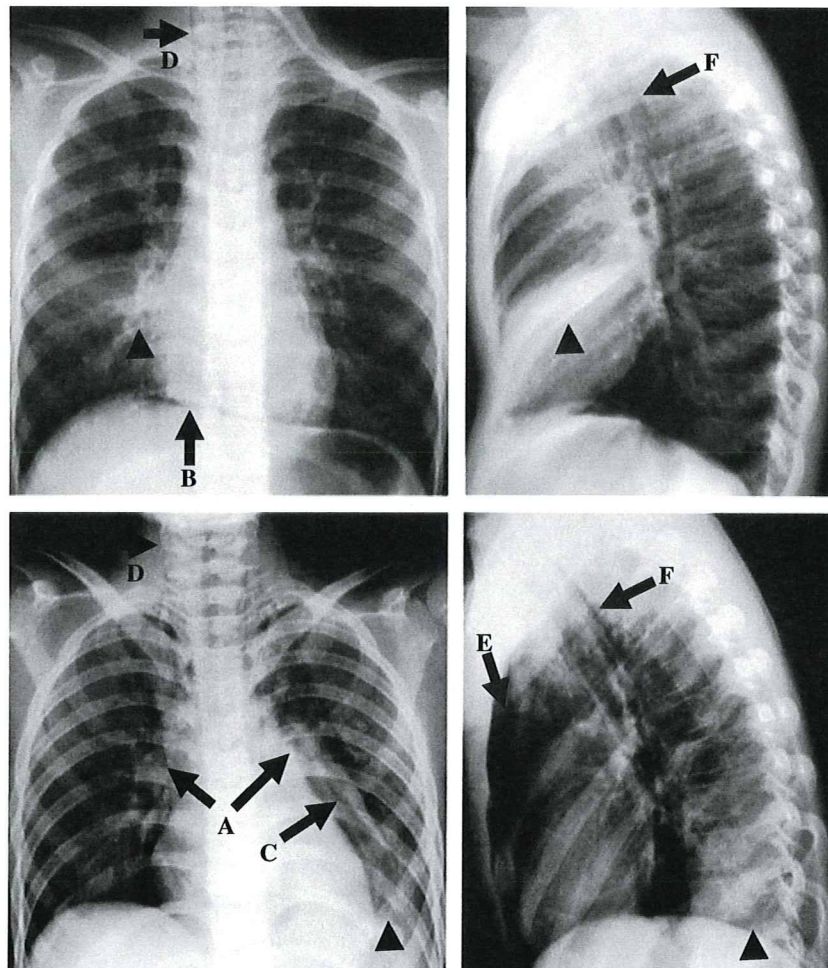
Chest roentgenograms showing spontaneous pneumomediastinum (arrows) complicating pneumonia in two children (case 1, upper row; case 2, lower row) infected with influenza A (H1N1) virus. The left images are frontal (posterior-anterior) views, and the right images are lateral views. Arrowheads indicate pulmonary infiltrates in each patient. A, spinnaker sail sign (angel wing sign); B, continuous diaphragm sign; C, vertical lucent streak on the left side of the heart; D, subcutaneous emphysema; E, retrosternal emphysema; F, posterior superior mediastinal emphysema.
